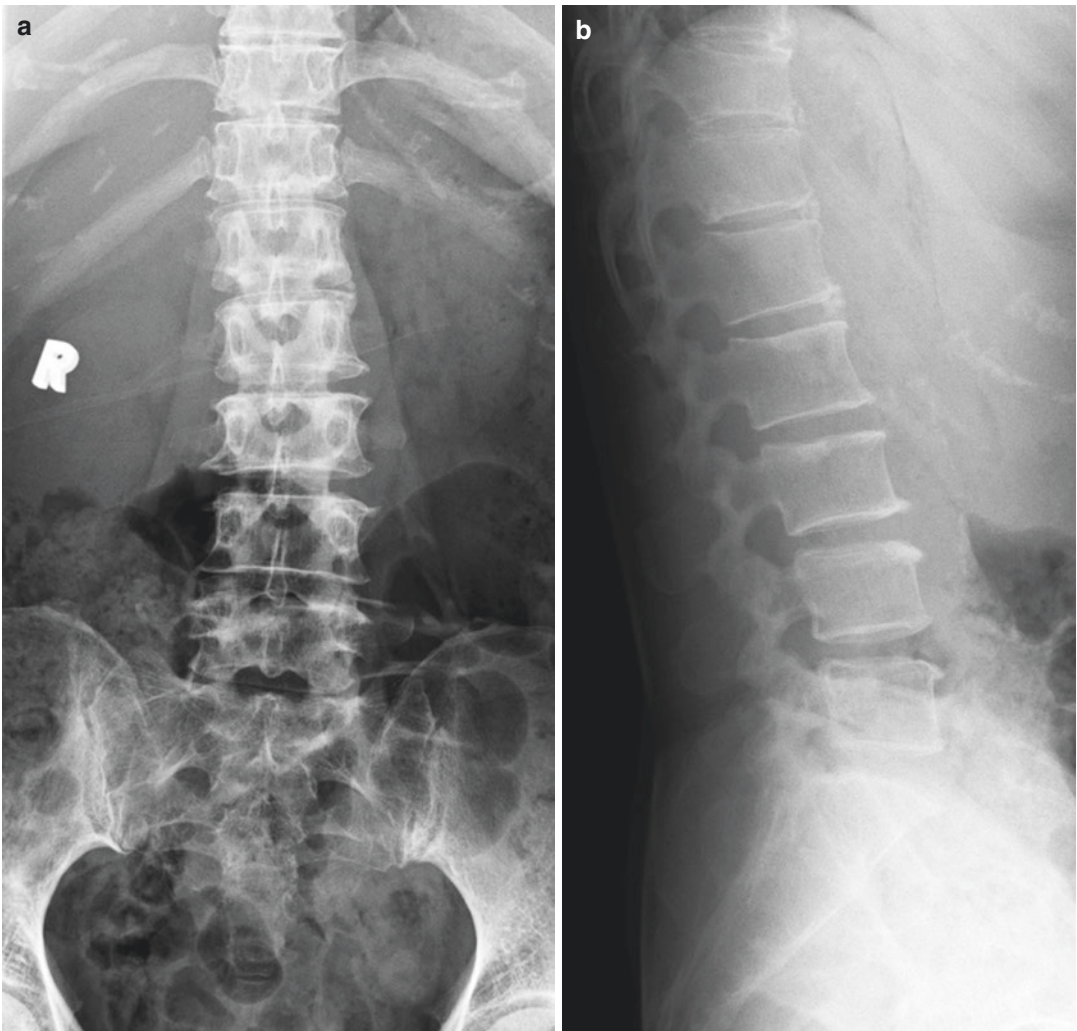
A 53-year-old woman who was recently diagnosed with adenocarcinoma of the right lung and presented with diffuse back pain. (a) Frontal and (b) lateral radiographs of the lumbar spine show spondylotic changes. Bone density is preserved and there is no evidence of osseous destruction. (c) Whole-body Tc-99 m
